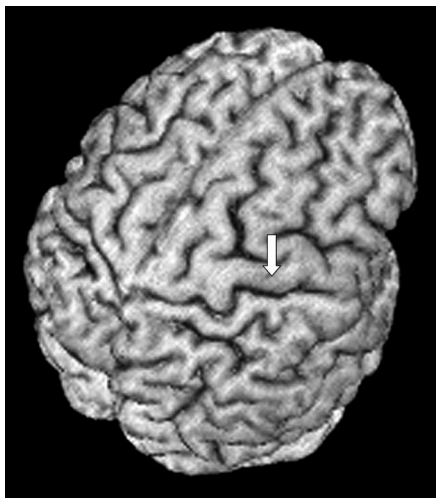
A three-dimensional MRI reconstruction (MRI-CRO software) of a patient's brain showing the central sulcus and precentral gyrus (*arrow*).
